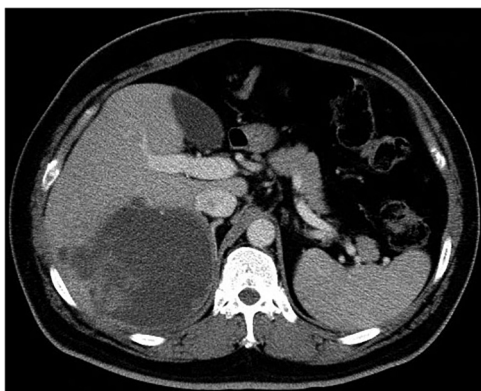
Abdominal computed tomography revealed a hypovascular cystic mass in segments 6 and 7 of the liver measuring 11.5 × 9.0 cm with ring enhancement and partial solid component.
